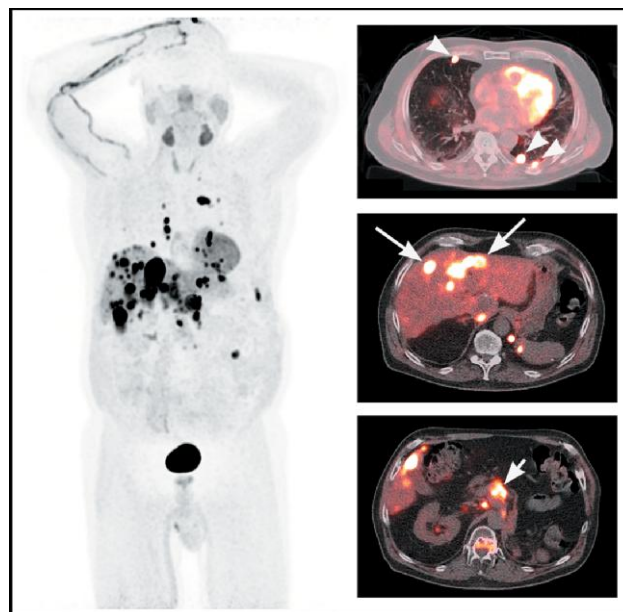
A 72-year-old man (patient 9) with a metastatic neuroendocrine tumor underwent radical left nephrectomy and had resection of a left pararenal mass. Postoperatively he had high normetanephrines, and urinary norepinephrine and dopamine levels. Positron emission tomography (PET) imaging was performed following intravenous injection of 306 MBq (8.3 mCi) of 3-[¹⁸F]fluoro-*para*-hydroxyphenethylguanidine (3-[¹⁸F]pHPG). Left: 3-[¹⁸F]pHPG MIP image at 90 minutes demonstrates multifocal metastases in the liver (standardized uptake value [SUV_{max}] of 103), abdominal and thoracic lymph nodes, lungs, and bones (SUV_{max} of 73). 3-[¹⁸F]pHPG activity is also seen in the parotid glands, thyroid, heart, liver, and pancreas, and there is genitourinary excretion of radiotracer in the kidneys and bladder. Right: Axial fused PET/CT slices showing intense 3-[¹⁸F]pHPG activity in malignant disease in the lungs (arrowheads, top), liver (long arrows, middle), and retroperitoneal abdominal nodes (short arrow, bottom). There is uptake in lytic/sclerotic bone metastases in the thoracic spine (bottom).
